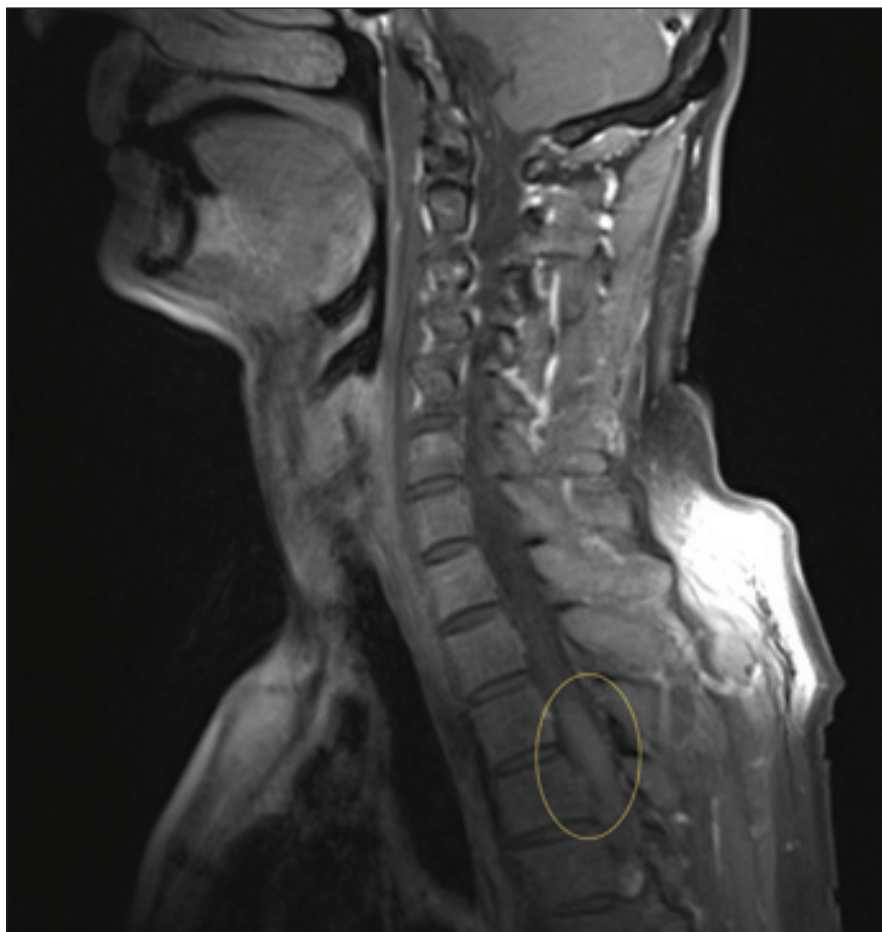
Thoracic lesion on an MRI scan in November 2024.
